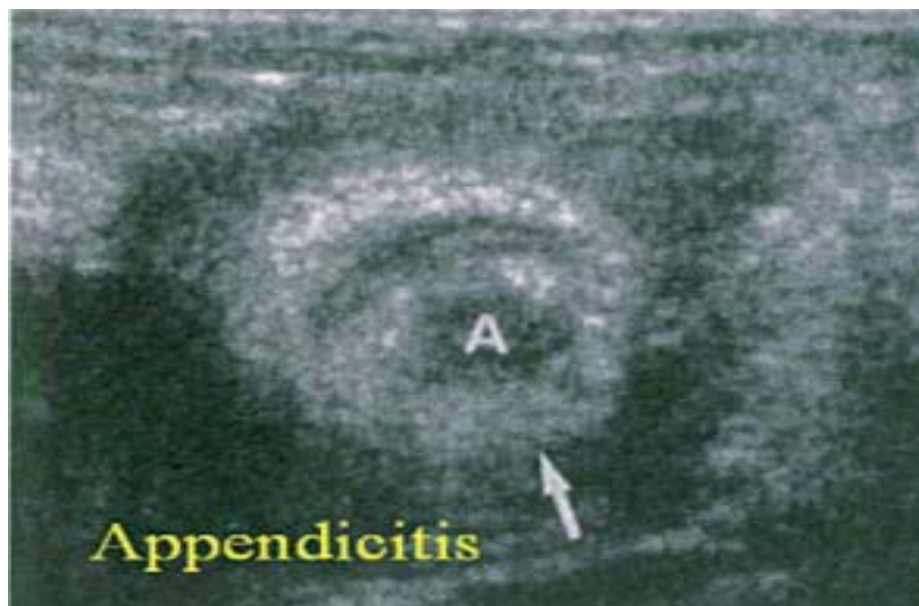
picture showing inflammed appendix on ultrasonography
